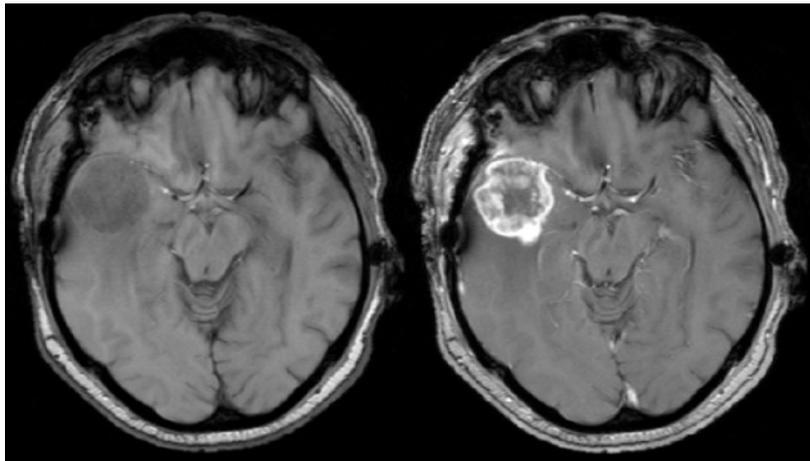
T_1 -weighted MRI without (left) and with (right) contrast agent
